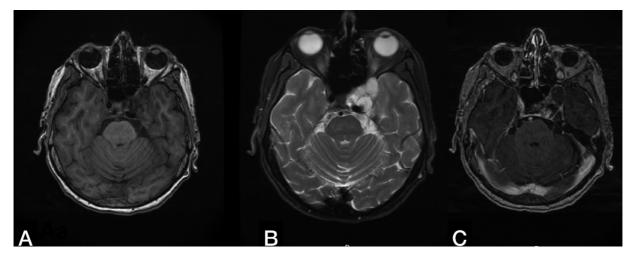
Preoperative axial T1-weighted (A), T2-weighted (B), and T1-weighted with contrast enhancement (C) MRIs show a cystic mass lesion with septations in the left cavernous sinus. Note the contrast enhancement in the cyst wall and septations.
